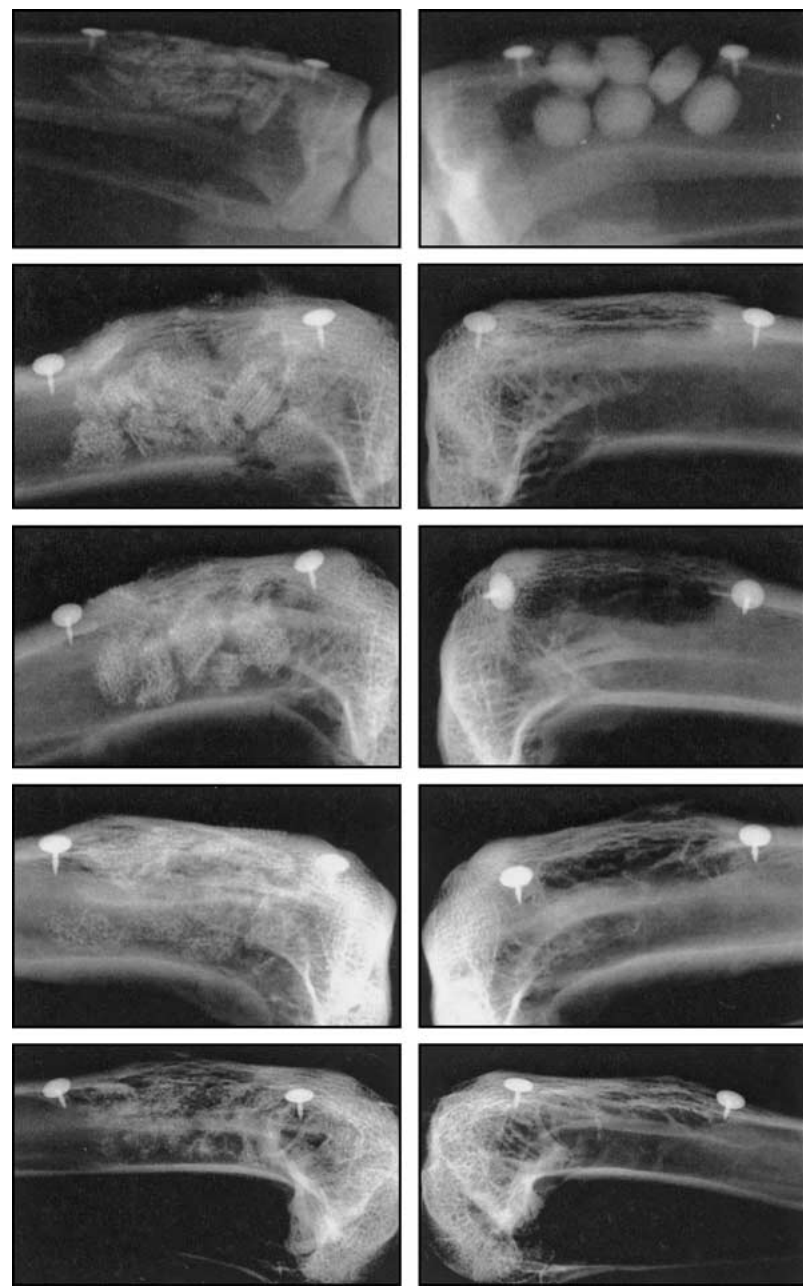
Radiographic comparison of HA/CC to POP. Left column: HA/CC immediately post-operatively at 6 weeks, 12 weeks, 24 weeks, and 42 weeks, respectively. Right column: plaster of Paris immediately postoperatively at 6 weeks, 12 weeks, 24 weeks, and 42 weeks, respectively.
